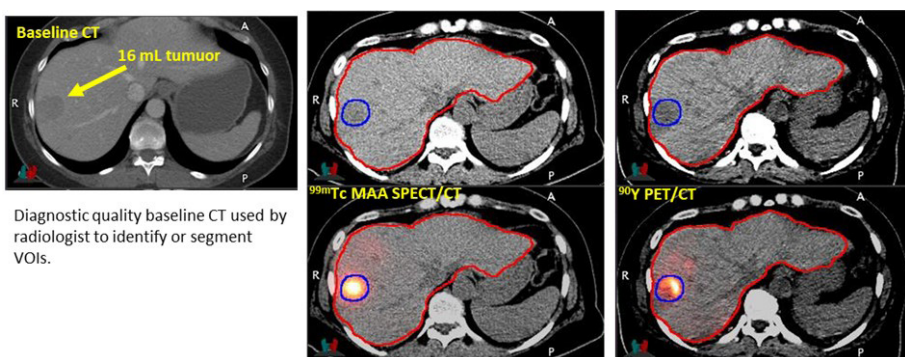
Images corresponding to a patient who underwent  $^{90}\text{Y}$  radioembolization with glass microspheres. In this example lesion and liver segmentation was performed directly on the CT of the SPECT/CT and PET/CT. Courtesy of Y. Dewaraja.
